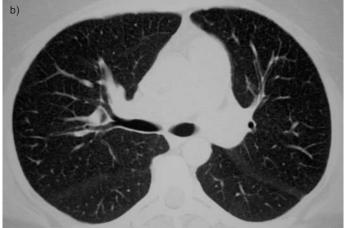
High-resolution computed tomography scan at tracheal carina level. a) Before treatment multiple small nodules and areas of ground-glass opacities with bilateral hilar enlarged nodes are visible. b) Following steroid treatment the abnormalities are no longer visible.
